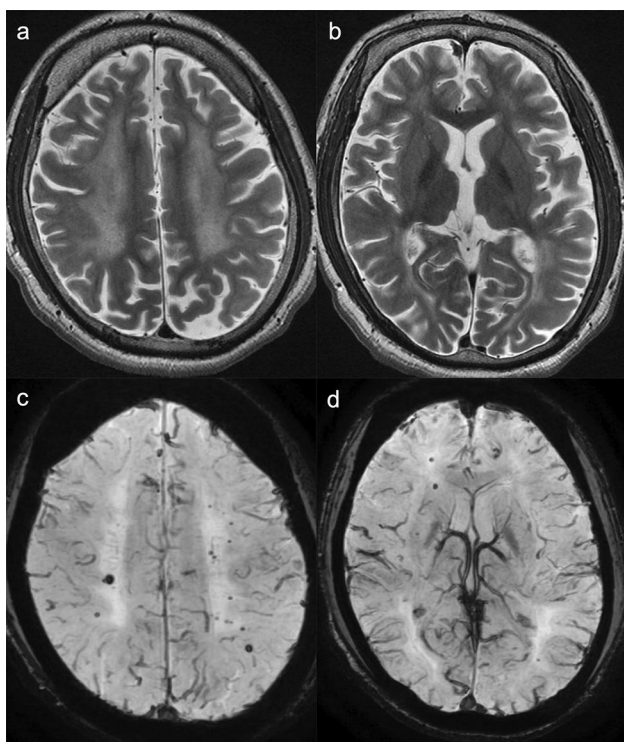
5,10-methylene-tetrahydrofolate reductase deficiency (MTHFRD) in an 18-year-old, male patient with epilepsy, intellectual disability, and an autistic tendency. The patient had lower limb motor weakness and urinary incontinence for 4 years. a, b Axial T2-weighted imaging demonstrated mild brain atrophy and white matter hyperintensities with posterior predominance. c, d Axial SWAN demonstrated multiple, cerebral microbleeds in the white matter (reprinted with permission from Reference [121]). SWAN, T2 star-weighted MR angiography
